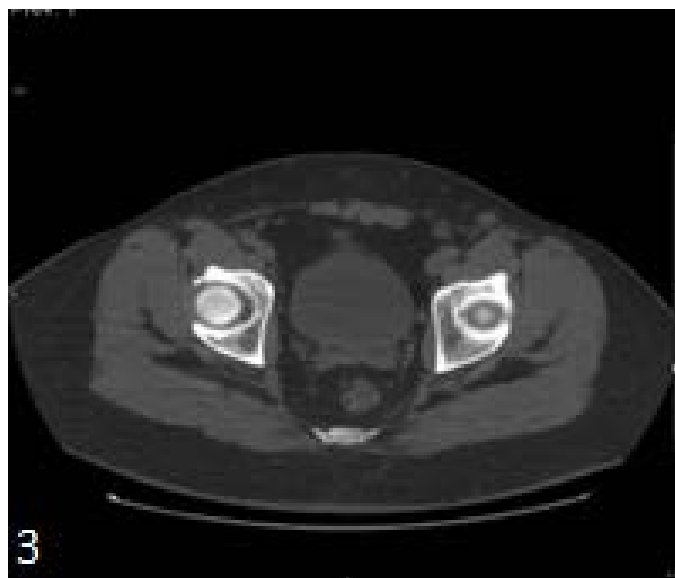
Axial non-contrast enhanced CT of the abdomen demonstrates an enlarged lymph node in the left inguinal region.
